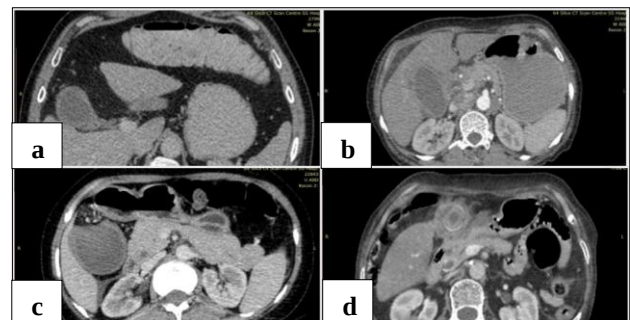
Contrast enhanced CT scan showing type V enhancement pattern in a thickened gall bladder wall, which is weakly enhancing, thin inner layer with a non-enhancing thin outer layer. The enhancement pattern is shown in (a) and (b). Various accompanying pathologies which are shown (c) a non-visualized pericholecystic fascia, and (d) presence of pericholecystic fluid.
